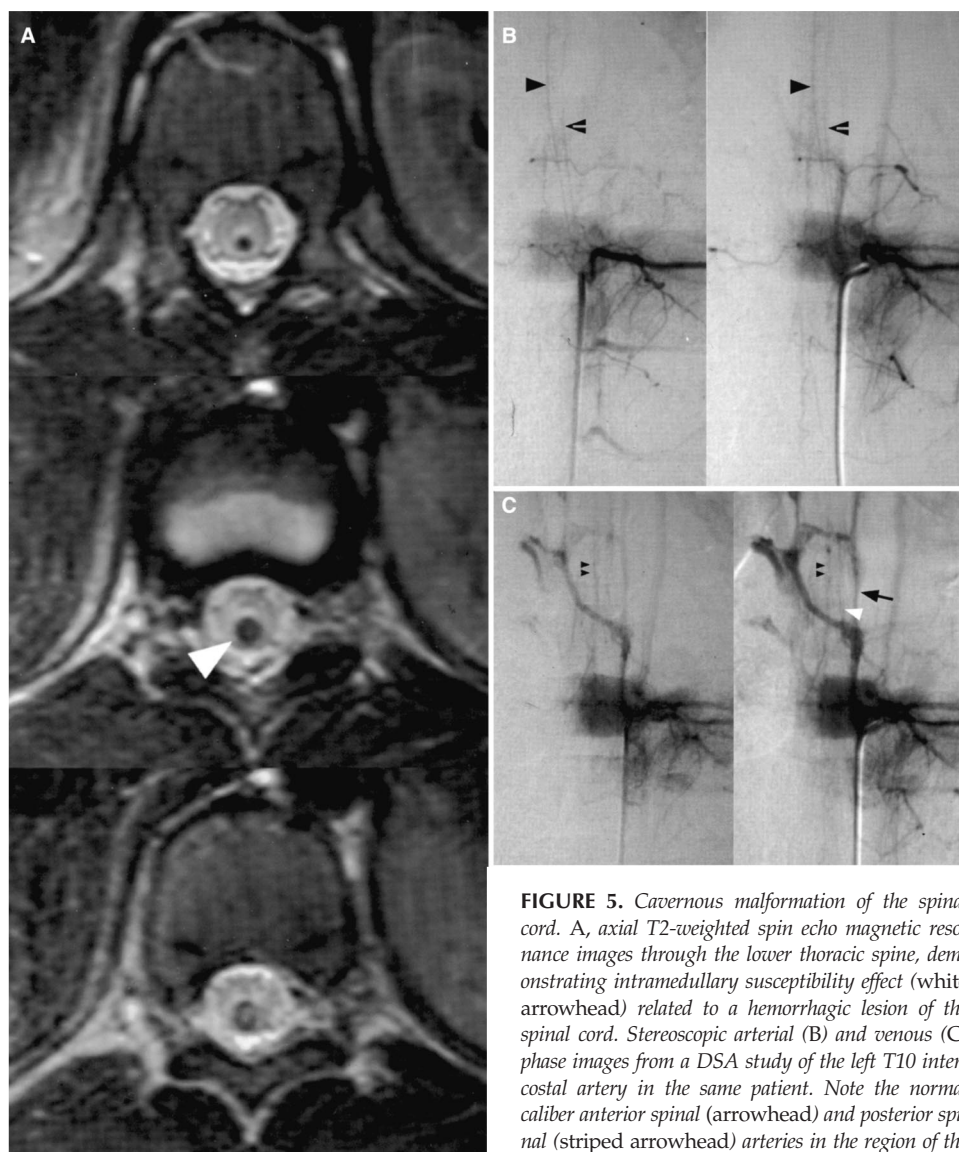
Cavernous malformation of the spinal cord. A, axial T2-weighted spin echo magnetic resonance images through the lower thoracic spine, demonstrating intramedullary susceptibility effect (white arrowhead) related to a hemorrhagic lesion of the spinal cord. Stereoscopic arterial (B) and venous (C) phase images from a DSA study of the left T10 intercostal artery in the same patient. Note the normal caliber anterior spinal (arrowhead) and posterior spinal (striped arrowhead) arteries in the region of the T9 hemorrhagic lesion. No evidence of arterial venous
